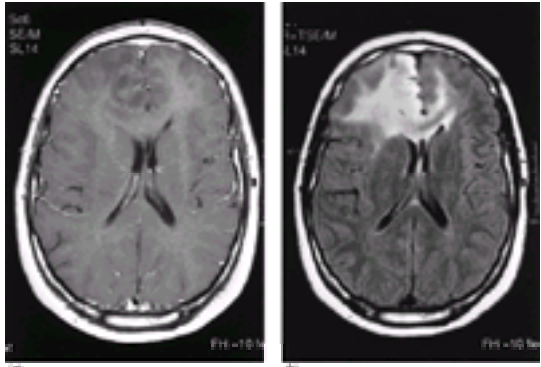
Anaplastic astrocytoma. (a) Axial T₁-weighted gadolinium-enhanced MRI demonstrating a right mesial frontal mass with faint gyriform enhancement and decreased signal intensity of the associated gyral white-matter tracts. (b) Axial FLAIR (TR 7000, TE 130) MRI better demonstrating the edema and infiltrative nature of this lesion, with involvement of not only the corpus callosum but also the left frontal lobe.
